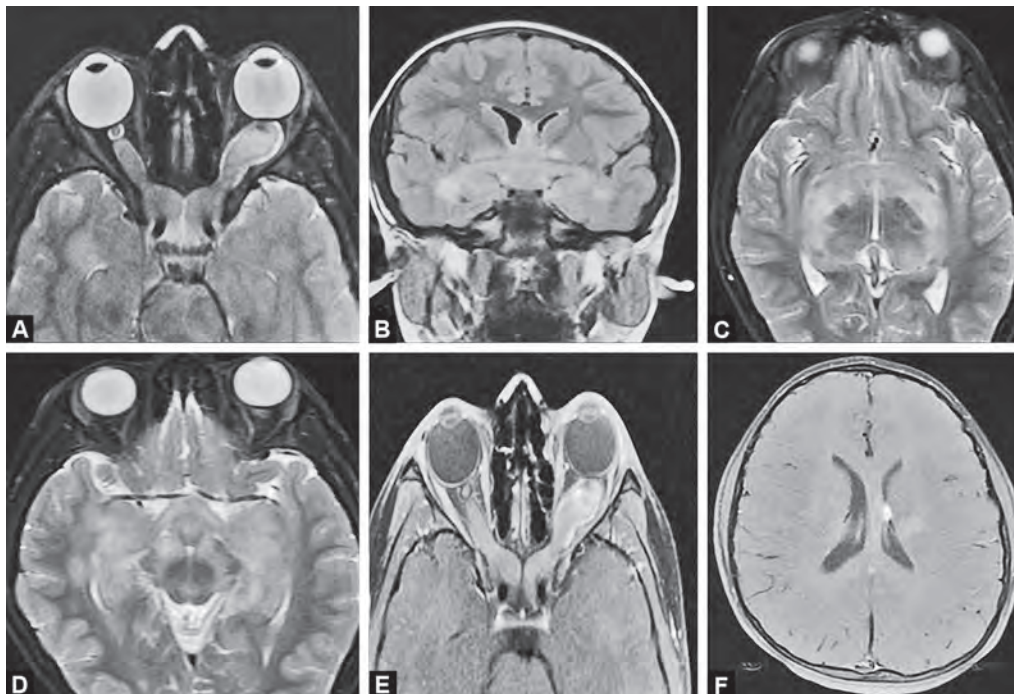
(A) Axial T2 image shows both optic nerves demonstrating fusiform thickening and tortuosity, patchy areas of T2 hyperintensities (left>right), and widening of the optic canals. (B) Coronal FLAIR and (C,D) axial T2 images show confluent hyperintensities involving the optic tracts, anterior commissure, both fornices, inferior aspects of both lentiform nuclei, thalami, hypothalamus, and both medial temporal lobes. (E,F) Axial post contrast fat-suppressed T1 images show relatively homogeneous enhancement of the intraorbital segment of the left optic nerve. A nodular focus of enhancement is seen in the intraventricular aspect of the body of the left lateral ventricle
